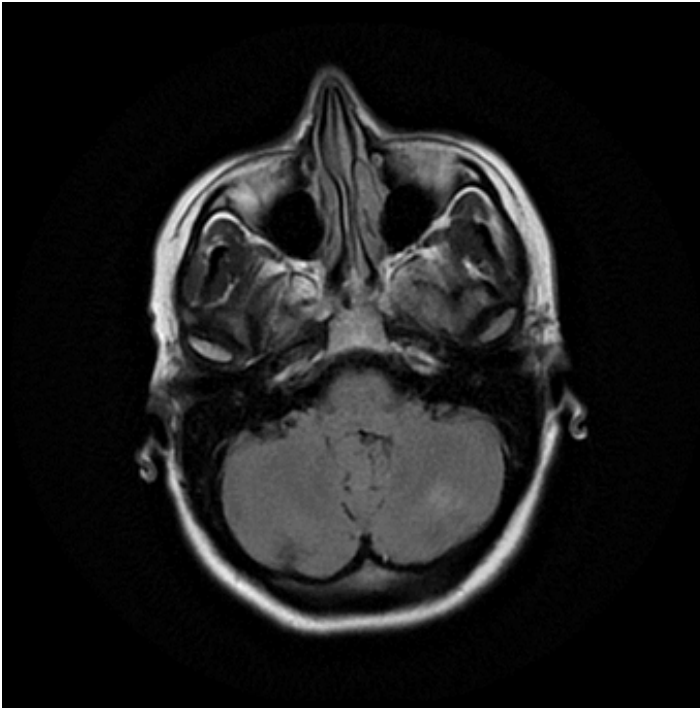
Magnetic resonance imaging scan showing wedge-shaped area of increased signal in the left cerebellar hemisphere (T2 and FLAIR sequences).
